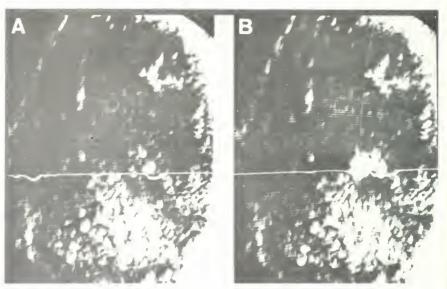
Coronal two dimensional ultrasound scans of a human brain containing an inferior parietal Glbm (Table 1, #3). A before and B a few seconds after a high intensity focused ultrasound lesion was made in the superior edge of the tumor, where the cross hairs intersect. The falx can be seen angulating from superior to inferior in the upper left portion of each scan.
